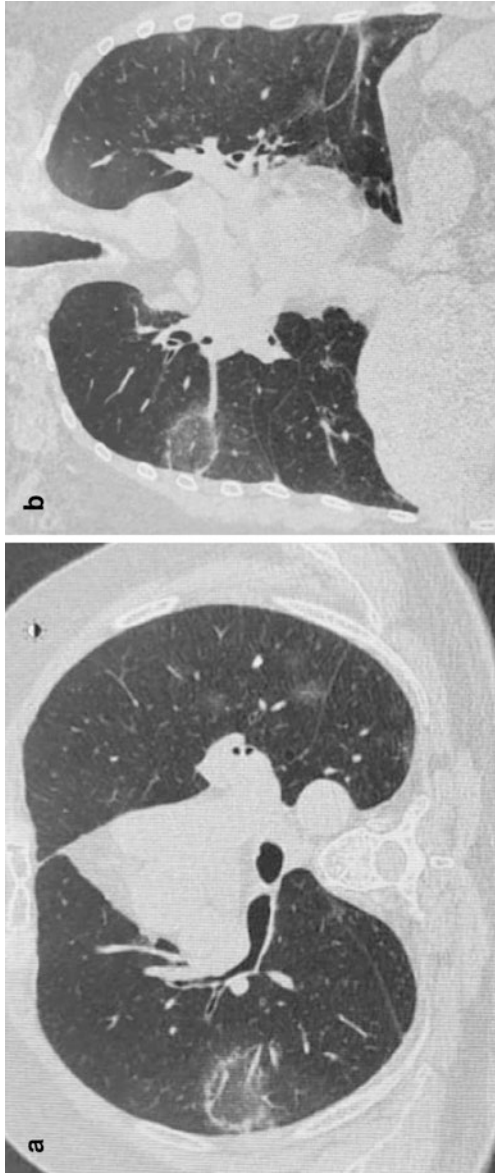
A 72-year-old male, known case of multiple myeloma on chemotherapy, presented with mild fever, cough, and myalgia. CT scan chest (a, axial view and b, coronal view) shows a peripheral ground glass opacity with consolidation in right lower lobe and few pure ground-glass opacities in left lower lobe, with fibrous stripes
